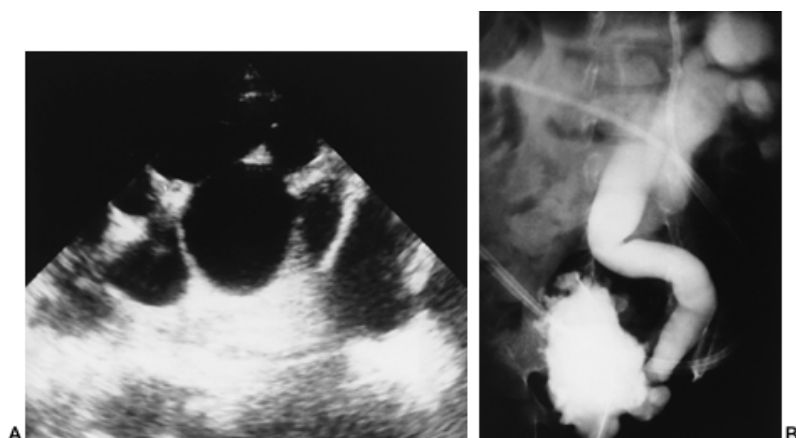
8. Vesicoureteral reflux and dysplasia (VURD) syndrome demonstrated on ultrasound (A) and VCUG (B).
